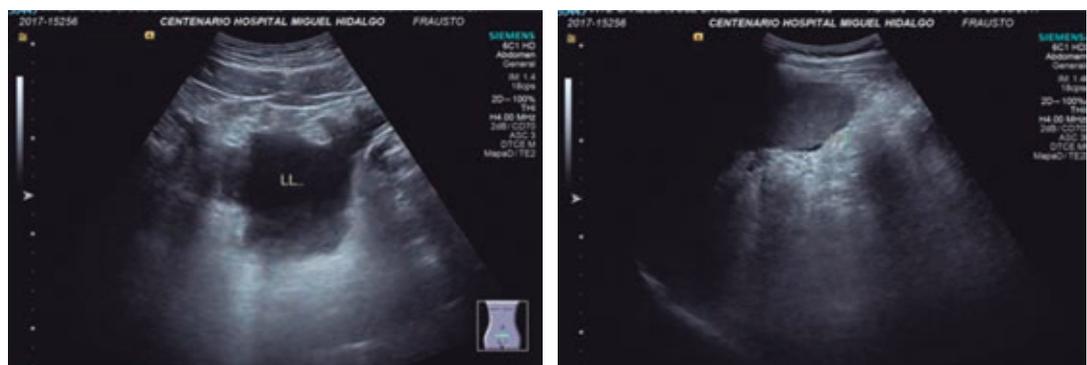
Ultrasound scan showing free fluid.
